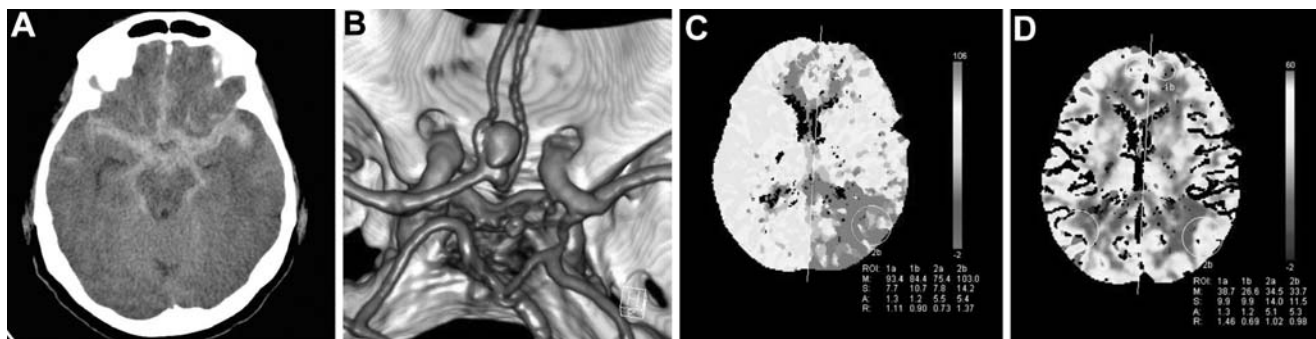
a CT on admission, showing excessive SAH (Fisher grade 3, Hunt & Hess grade 5). b Aneurysm of the anterior communicating artery detected in computed tomography angiography. c, d CT perfusion:
